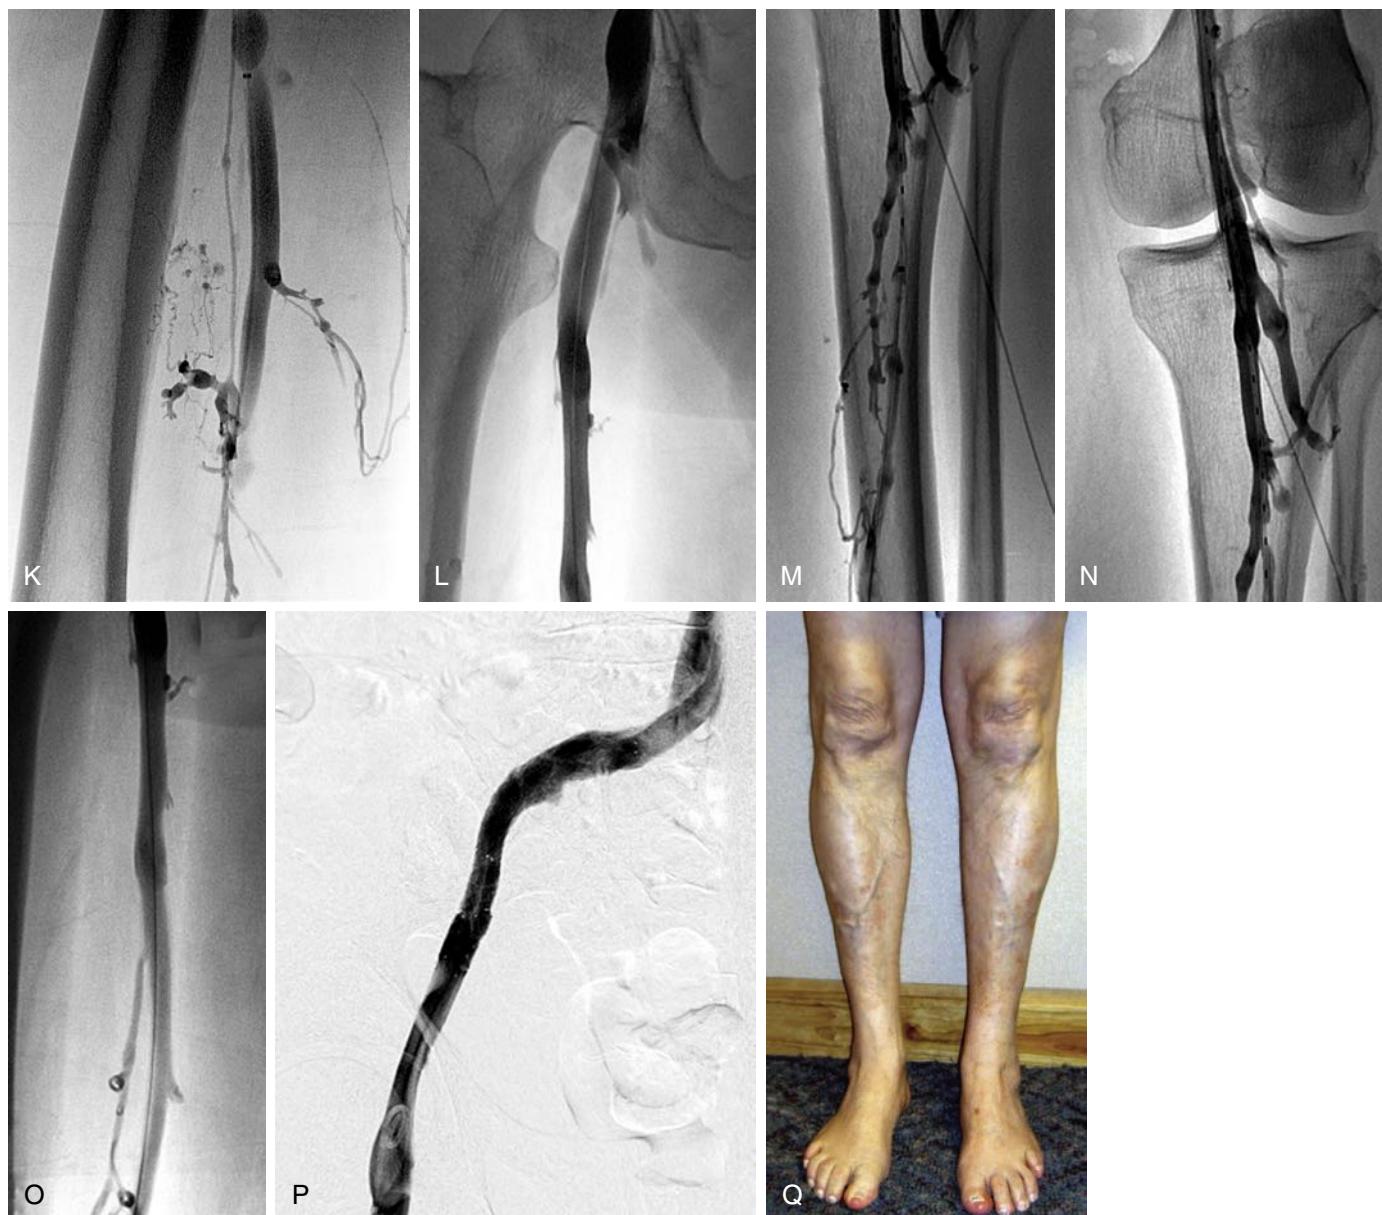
A 65-year-old man was referred with phlegmasia cerulea dolens of his left leg (A) 36 hours after major abdominal laparotomy. Venous duplex demonstrated clot in the posterior tibial veins extending to the external iliac vein. A contrast-enhanced computed tomography (CT) scan of the chest, abdomen, and pelvis was performed and demonstrated asymptomatic pulmonary emboli (B) and mediastinal (C, arrows), and pelvic lymphadenopathy (D, arrows). The extensive thrombus is demonstrated by a catheter phlebogram of the femoral vein (E and F) and the silhouette of the calf thrombus (G) by the catheter in the posterior tibial vein at the ankle.
